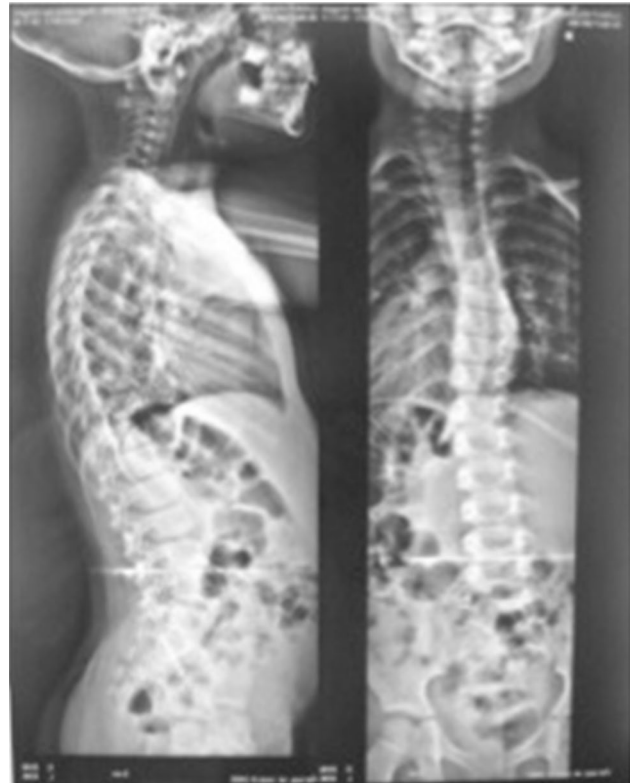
AP plain film X-ray of twin B demonstrating a left T1 hemivertebra and right T7 hemivertebra, both of which were fused to adjacent vertebra
